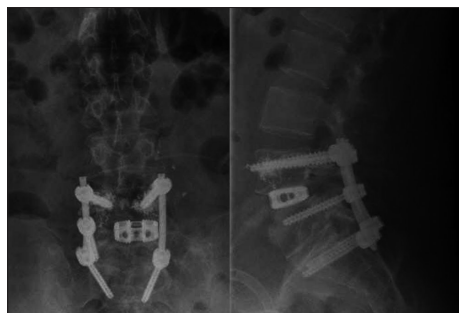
Plain radiographs after the second revision surgery showing the removal of the left L5 screw and bilateral extension of the pedicle screw fixation to S1.
